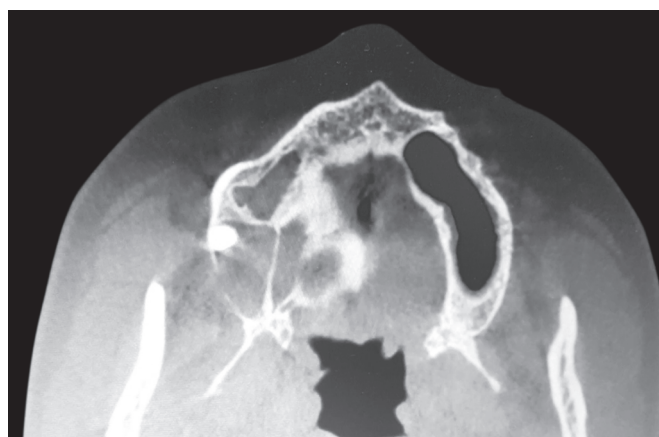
Axial view of the CBCT showing an ectopic right maxillary third molar associated with a hypodense lesion in the posterior region of maxilla. The maxillary sinus is retrieved by the lesion and the alveolar recess is filled
